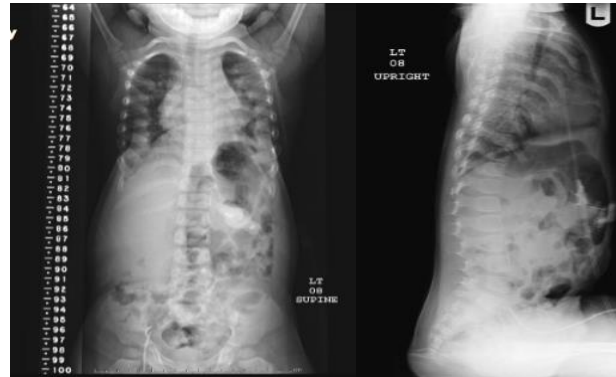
Frontal and lateral x-ray of patient with asphyxiating thoracic dystrophy; characterised by the bell-shaped thorax seen on the left and horizontally oriented ribs. Images taken from
